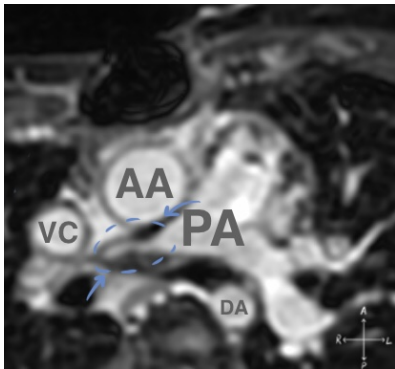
MRI scan that shows the disparity in sizes of the left and right branches of the pulmonary artery. The right branch is very small in contrast with the left branch (blue circles and arrows). Axial view.
